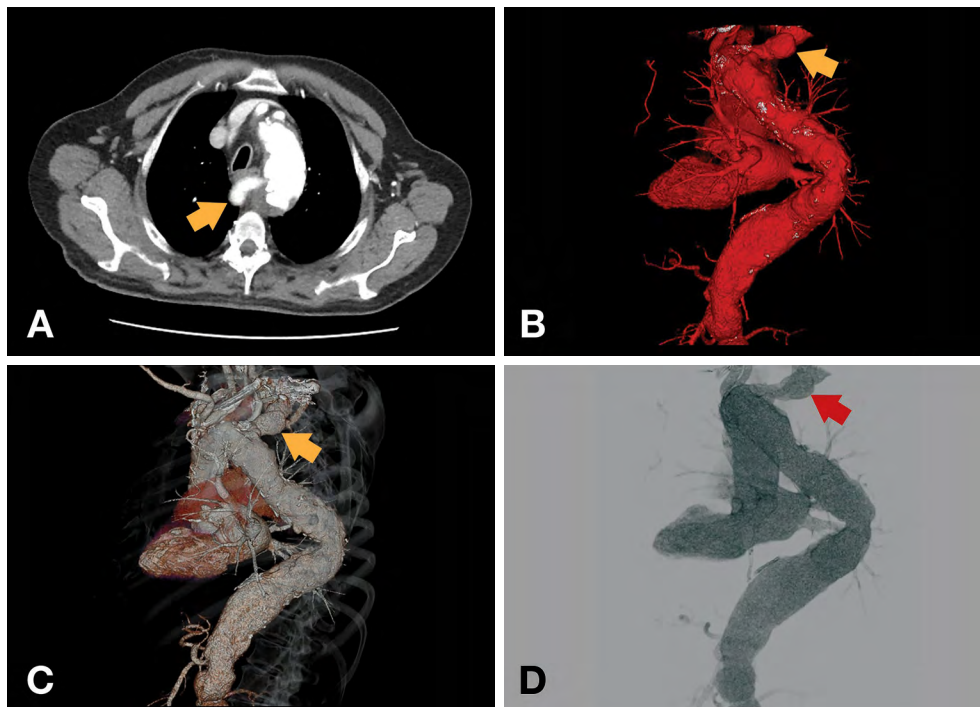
Thoracic contrasted computed tomography images of aberrant right subclavian artery aneurysm.
